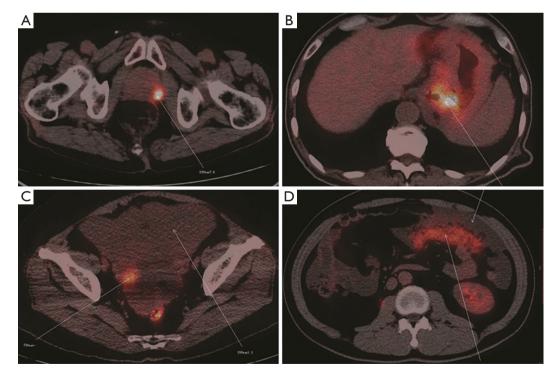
SUV_{max} of cancers with different sites. (A) Prostate SUV_{max} 7.6; (B) Gastrointestinal tract SUV_{max} 7.4; (C) Ovary SUV_{max} 5.2; (D) Peritoneal SUV_{max} 6.2.
